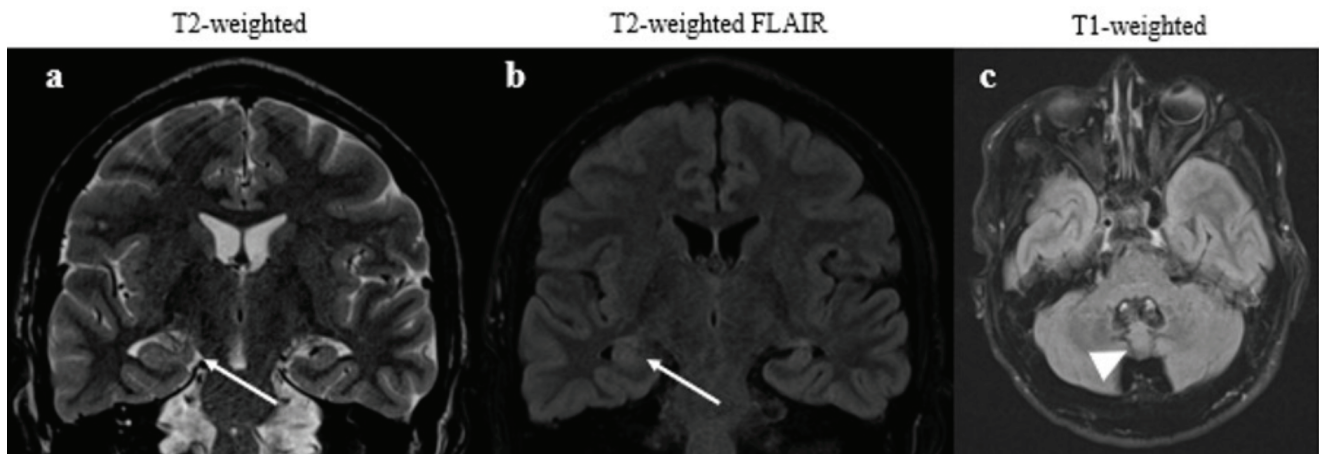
Thirty-five-year-old man patient with Down syndrome admitted to hospital with forgetting tasks, decrease in expression of wants/desires. After an episode leading to a fall/presumed seizure 5 years ago, his cognition and demeanor have changed. Electroencephalography revealed stiffening behaviors that are inconsistent with seizures. The Montreal Cognitive Assessment score was 6/30. Brain magnetic resonance imaging revealed mild volume loss of both hippocampi without abnormal T2/FLAIR signal, which likely represents degenerative changes associated with Trisomy-21 (a and b; arrows). Vermian hypoplasia with prominent extra-axial spaces was detected (c; arrowhead).
